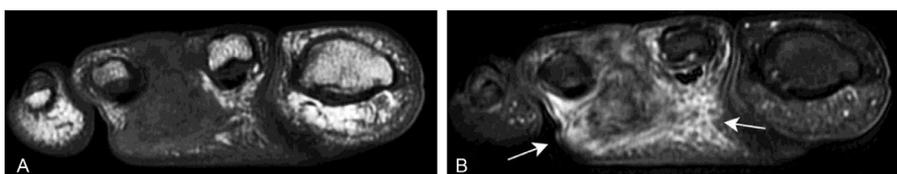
Clear cell sarcoma. (A) Coronal short-axis T1WI shows a large, lobulated, and infiltrative mass in the foot that is slightly hyperintense than the muscle. (B) On coronal short-axis fat saturated T2WI, the mass is hypointense with marked peritumoral edema (white arrows). T1WI, T1-weighted images; T2WI, T2-weighted images.
